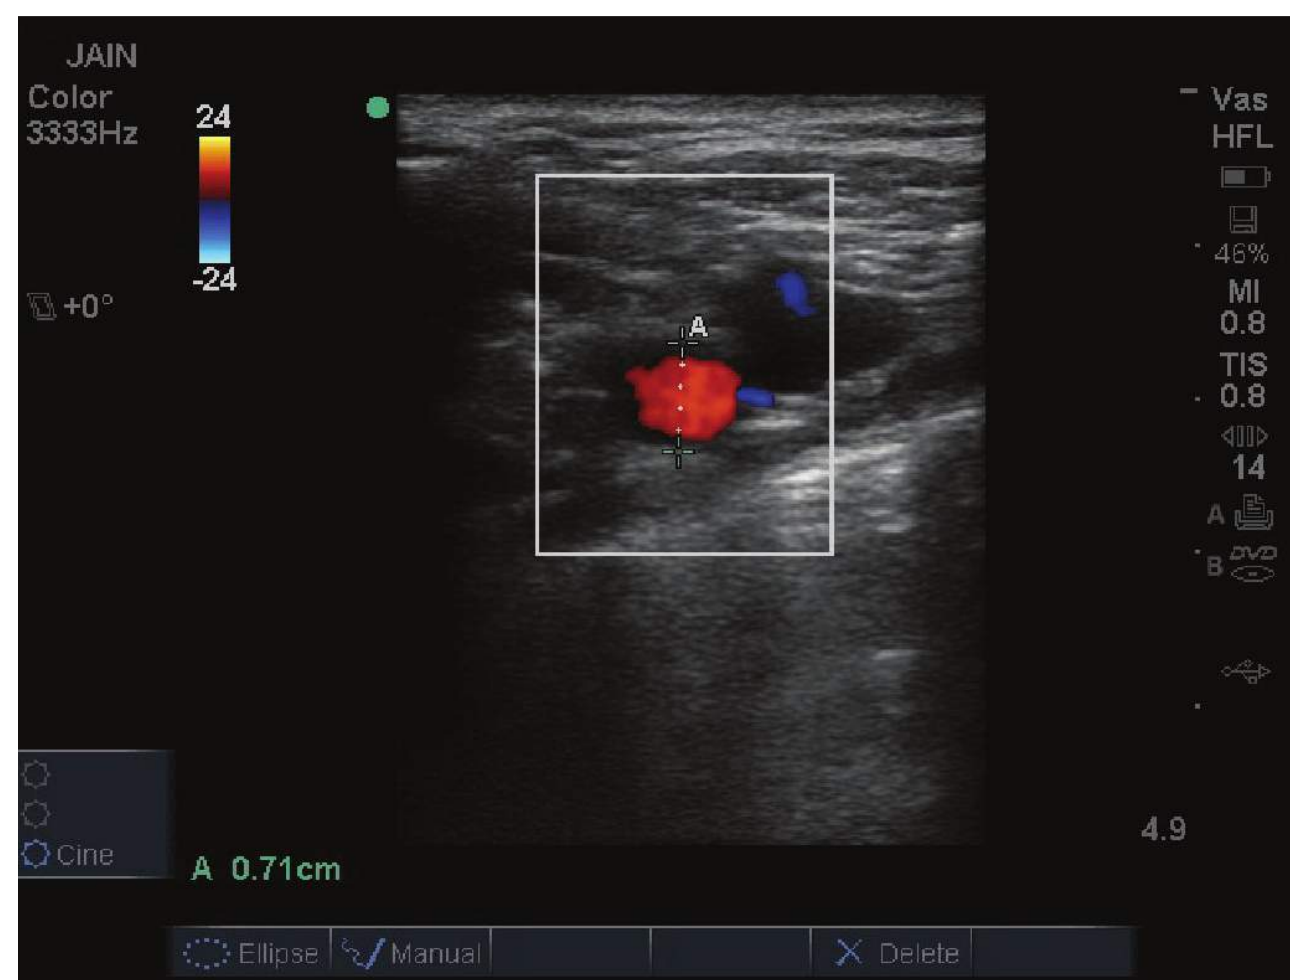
B-mode image with color Doppler to confirm artery versus vein for subclavian minimum diameter in the same patient in Figure 55-5.
